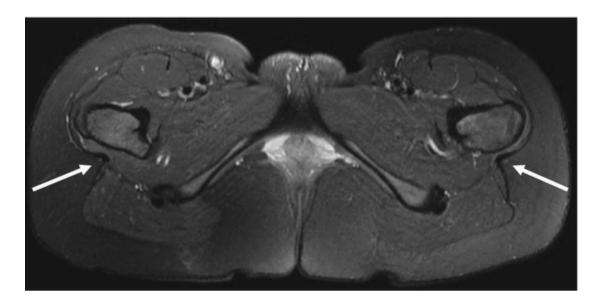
A14-year-old girl with bilateral hip snapping, painful on the left. A sickle deformity of the gluteus maximus tendons, characterized by a deep location of the myotendinous junction posterior to the great trochanter is seen bilaterally on this axial fat-suppressed T2-weighted MRI (*arrows*)
